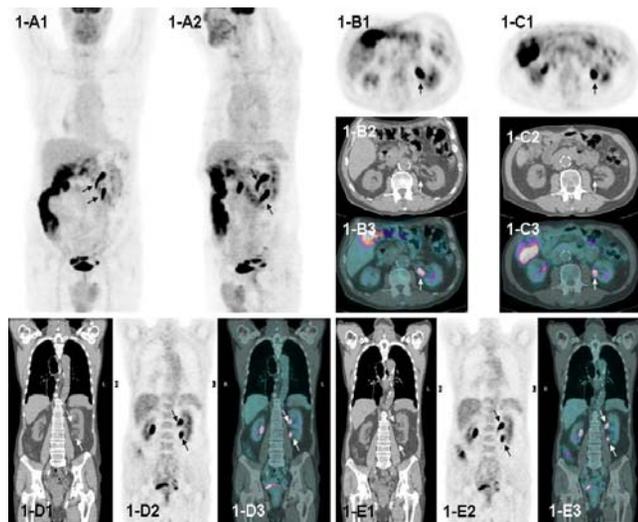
Anterior view (1-A1) and left oblique anterior view at 45° (1-A2) of maximum intensity projection show double left kidney collecting system (arrows). Axial PET (1-B1), CT (1-B2), fused (1-B3) images show lower pelvis (arrows); axial PET (1-C1), CT (1-C2), fused (1-C3) images show upper pelvis (arrows); coronal CT (1-D1;1-E1), PET (1-D2;1-E2) and fused (1-D3;1-E3) images show both pelvis (arrows).
